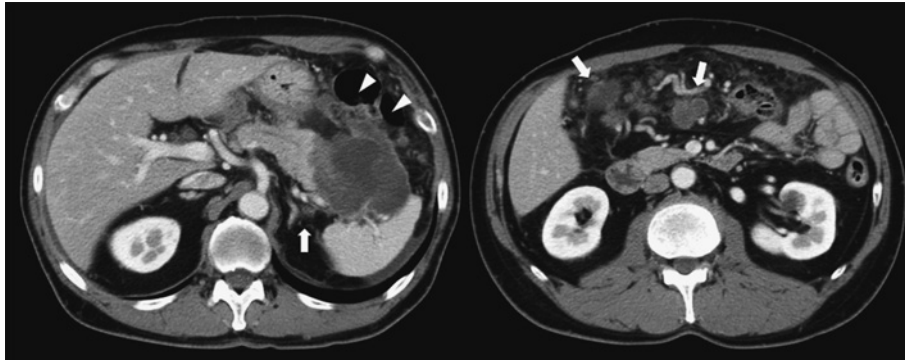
CT image of Case 3 before the start of neoadjuvant chemotherapy. Extrapancreatic invasion of the main tumor is present, as is invasion of the fusion fascia of Toldt and deeper. Invasion of the transverse mesocolon and transverse colon is suspected (arrowheads). Furthermore, several disseminations within the omental bursa can be seen (arrows).
